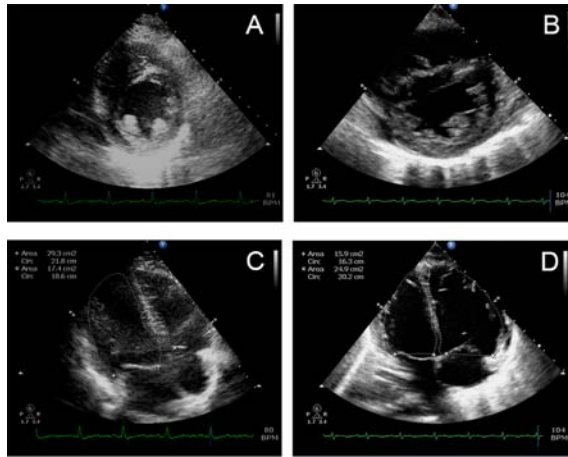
The morphology of the LV and the RV: A) Parasternal short axis view showed cross sectional views of a normal LV. The RV appears as a crescentic structure, covering the left upper quadrant of the LV. B) Parasternal short axis view of a patient with RV dysfunction shows LV D-shape. C) Apical 4-chamber view shows LV on the left side and RV on the right side of picture. Normal RVEDA and RVESA are smaller than LVEDA and LVESA. The RV apex appears as a triangular shape and finishes before the LV apex. D) Apical 4-chamber view of a patient with RV dysfunction shows dilation of the RV with loss of the RV apical triangle.
